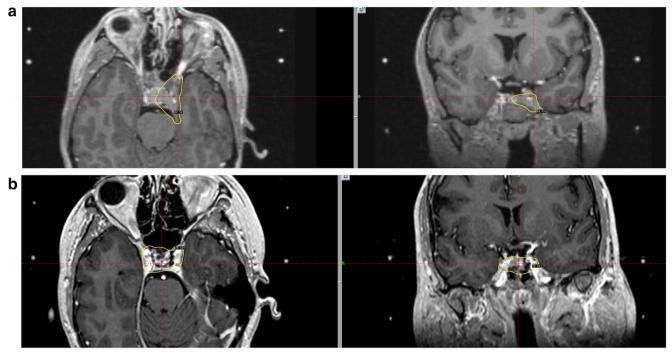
Treatment plans of discrete adenoma as seen on SRS planning brain MRI (panel a) and the whole sella in a patient without clearly evident adenoma on SRS planning brain MRI (panel b). Yellow line
